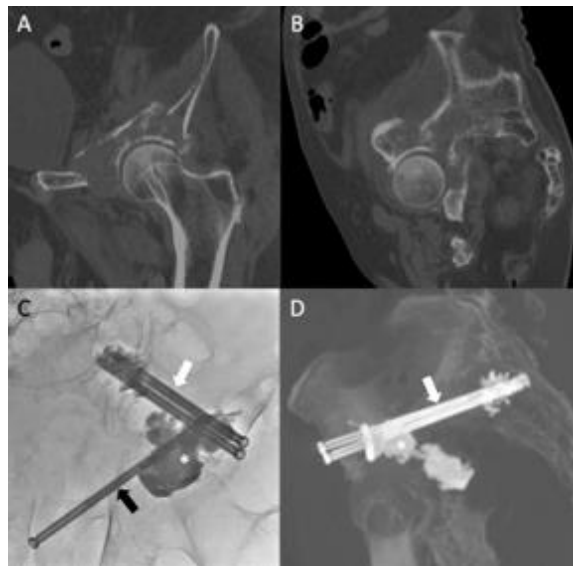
Combined screw fixation and cementoplasty to consolidate a complex acetabular pathological fracture. (A) Coronal oblique and (B) Sagittal oblique CT-scan show a displaced pathological fracture of the acetabulum, in a patient not eligible for surgery. (C) AP fluoro projection and (D) Sagittal oblique CT-scan: Cementoplasty was performed to reinforce the acetabular roof (asterisk) in combination with one retrograde transpubic screw (black arrow) and two anterior trans-iliac screws (white arrow) for fracture fixation. Partial mechanical improvement was noted after the intervention.
